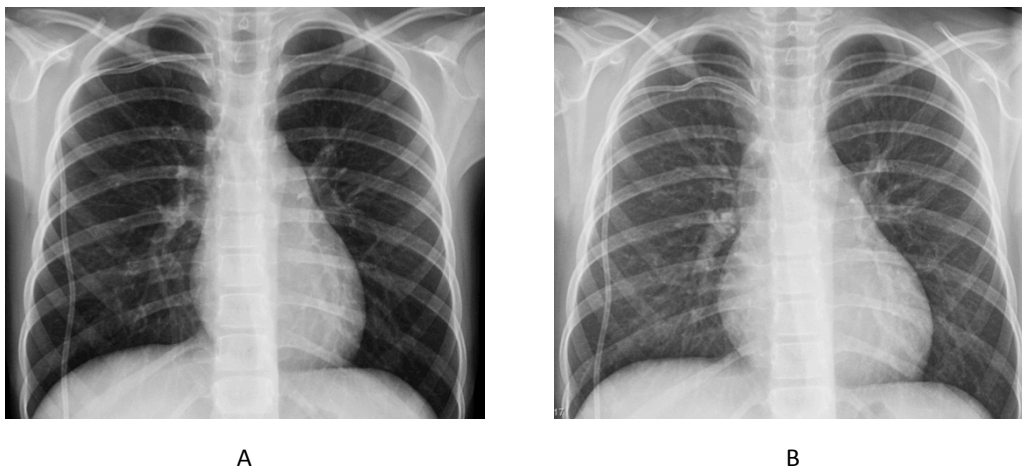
A: Chest plain radiography with AEC + central chamber; B: Chest plain radiography with AEC + lateral right chamber
